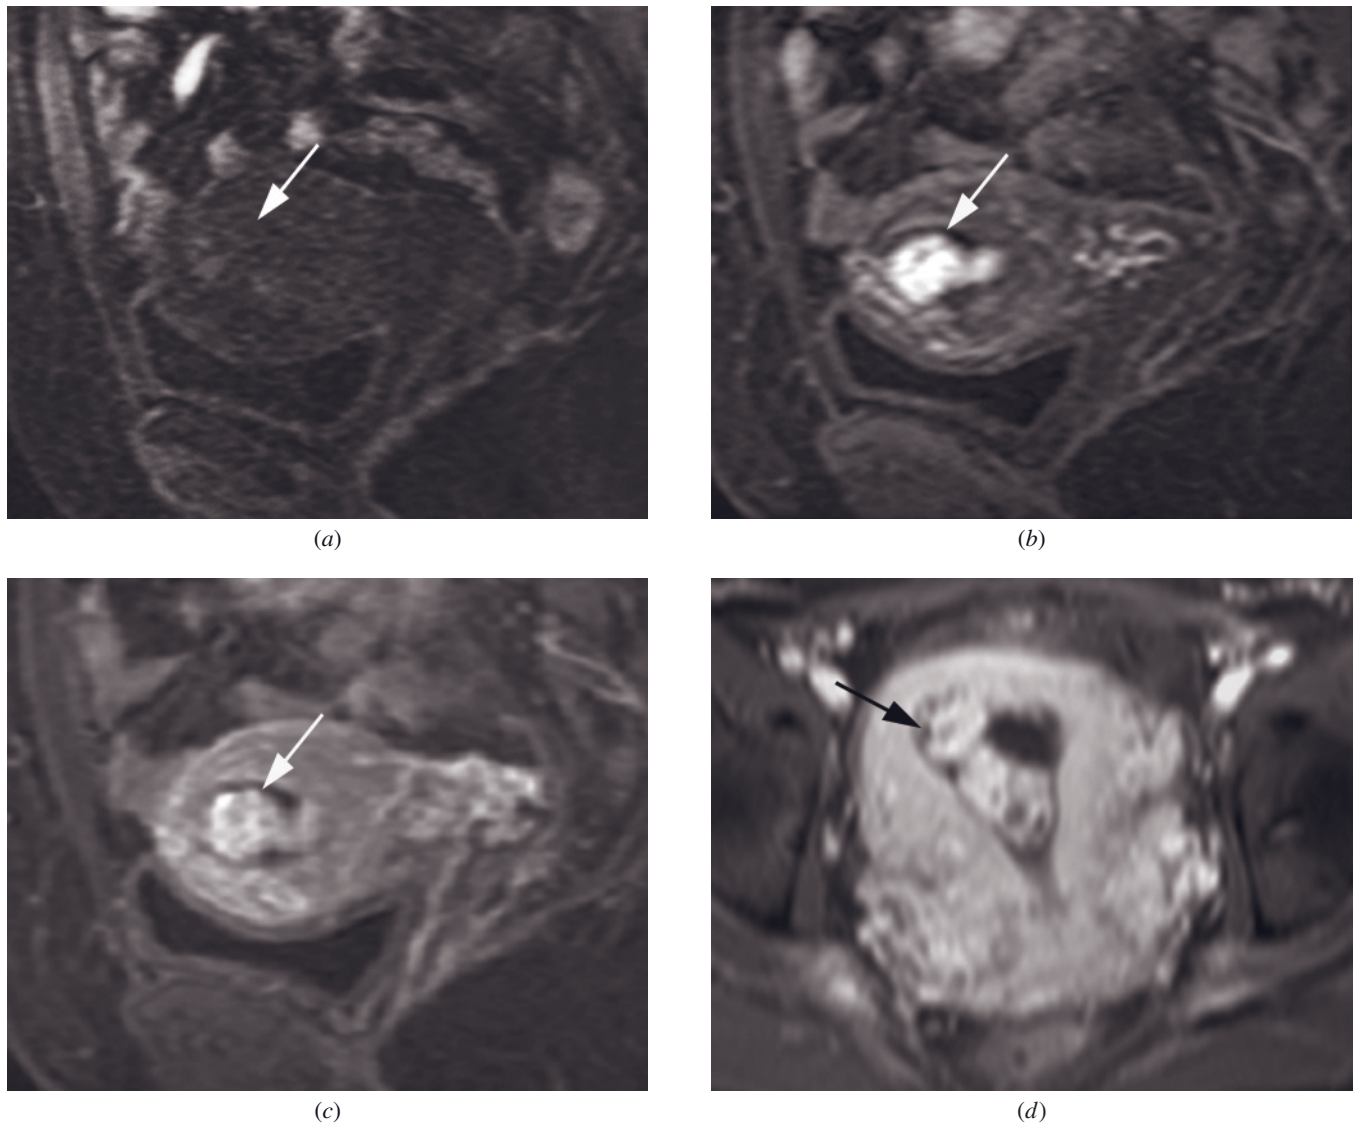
Retained products of conception. Sagittal fat-suppressed T1-weighted gradient echo images pre- (*a*) and post-gadolinium in arterial (*b*) and venous (*c*) phases, and transverse delayed postgadolinium fat suppressed T1-weighted gradient echo image (*d*) in a postpartum patient with vaginal bleeding. There is mass within the endometrial canal that is low signal intensity pre-contrast (arrow, *a*) and shows early and intense enhancement (arrow, *b*). The mass retains contrast on delayed images (arrow, *c*, *d*).
